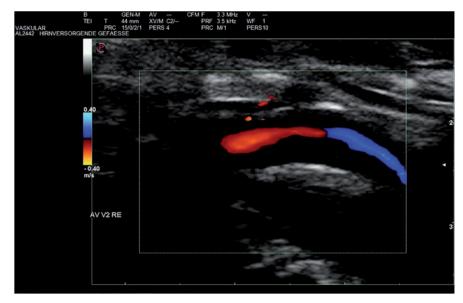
Colour duplex ultrasonography of the vertebral artery (longitudinal section). The circumferential hypoechogenic vessel-wall-thickening (vertebral-halo sign) is found in the vertebral artery in giant cell arteritis.
